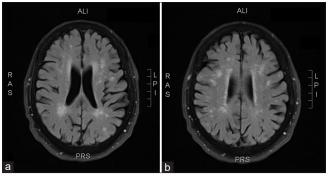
(a and b) Axial T2-weighted MRI flair images with deep white matter ischemic changes with multiple bilateral frontoparietal tiny ischemic foci
